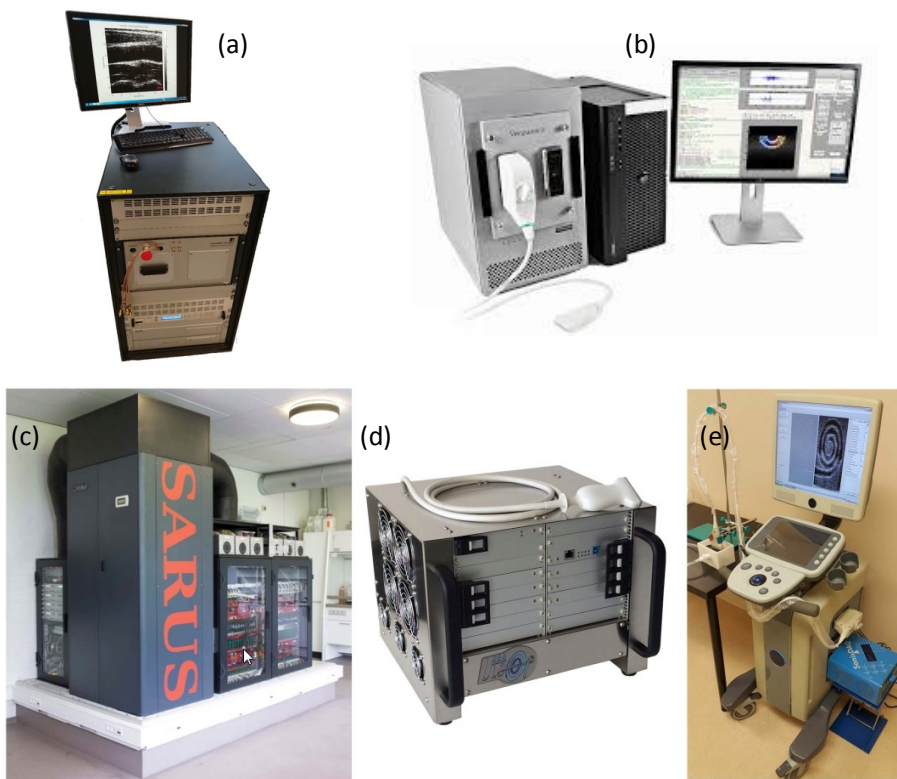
(a) Ultrasound Array Research Platform II (UARP II) developed by the Ultrasound Group at the University of Leeds (Nie *et al.*, 2018b). (b) Verasonics Vantage 256 (Kirkland, WA, USA). (c) Synthetic Aperture Real-time Ultrasound System (SARUS) developed at the Technical University of Denmark (Jensen *et al.*, 2013). (d) Ultrasound Advanced Open Platform 256 (ULA-OP 256) developed at the University of Florence (Boni *et al.*, 2016). (e) SonixTouch research scanner (Cheung *et al.*, 2012).
